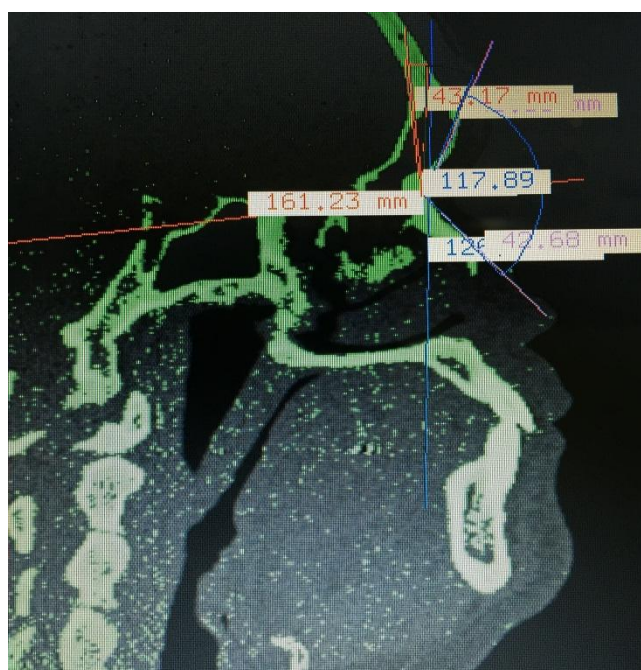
Representation of lines A, B, and C, and angles ANV, BNV, and BNC obtained from patients CT with software Invesalius.
